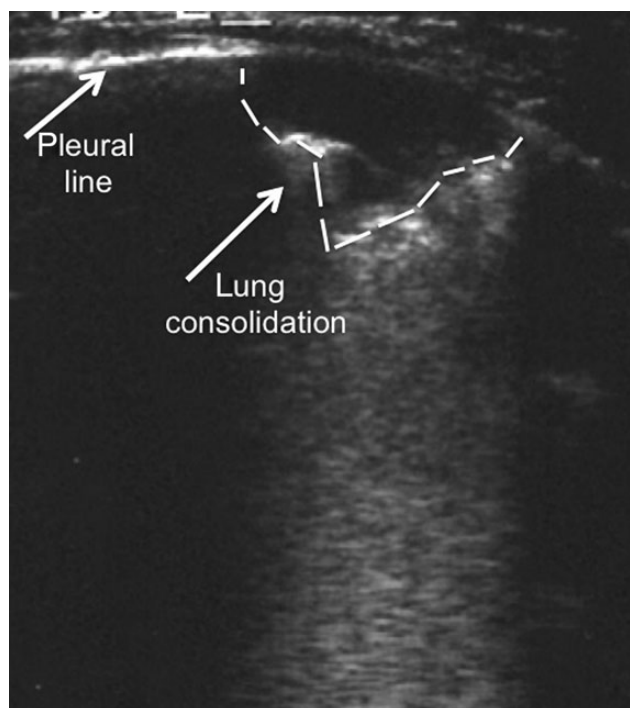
Sonographic appearance of a subpleural lung consolidation.
